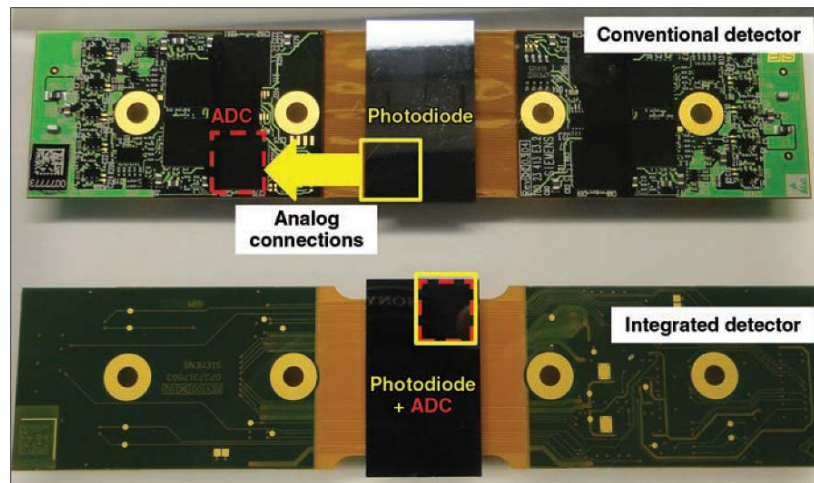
Photograph shows conventional CT detector module (top) (Somatom Definition AS+, Siemens Healthcare) and integrated CT detector module (bottom) (Stellar detector, Somatom Definition Flash, Siemens Healthcare) [45].
